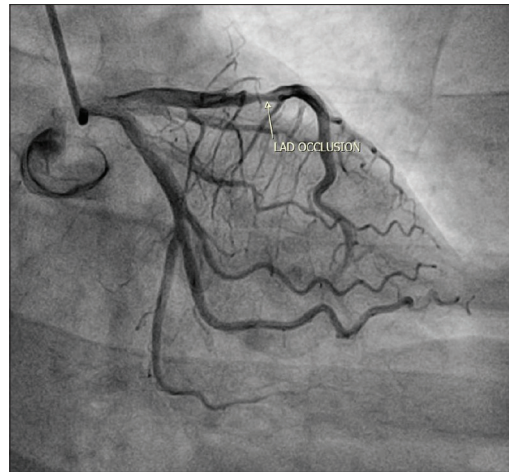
CT Coronary angiography showing 70% occlusion of the left anterior descending artery
